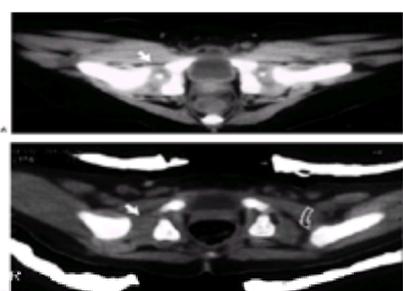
CT scanning to verify the position of a hip after dislocation of reduction and spica cast placement in two different infant girls. A: Normal anatomy. Both hips are located concentrically. The ossification centers are present. *Dotted lines* partially outline the contour of the right cartilaginous epiphysis. B: Redislocation of the left hip. The right hip is located concentrically (*closed arrow*). The left hip has redislocated posteriorly. The *open curved arrow* points to the left metaphysis, because the unossified epiphysis is not visible on this slice.
